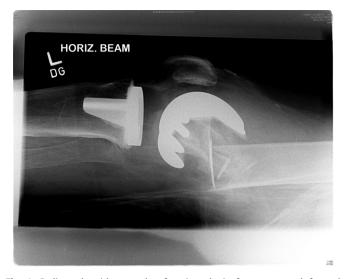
Radiograph with example of periprosthetic fracture around femoral component suitable for distal femoral replacement. Fracture line extends distal to proximal femoral border with loosening of component.
